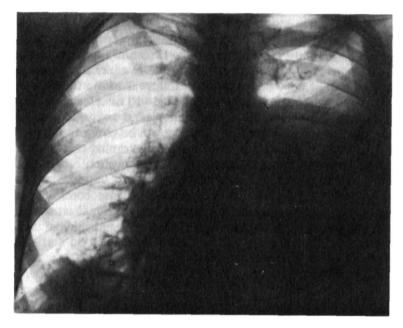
X-ray of the left lung in pleurisy with effusion.
